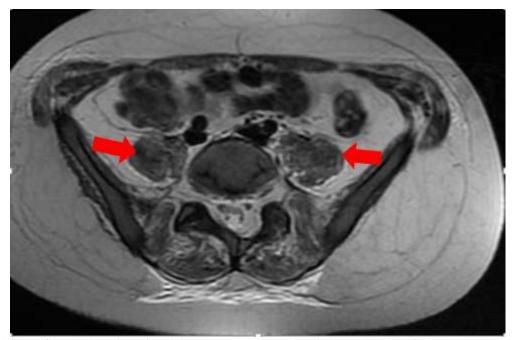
Axial section of apelvic MRI T2 sequenceshowinghypethrophy of the psoas muscle.
